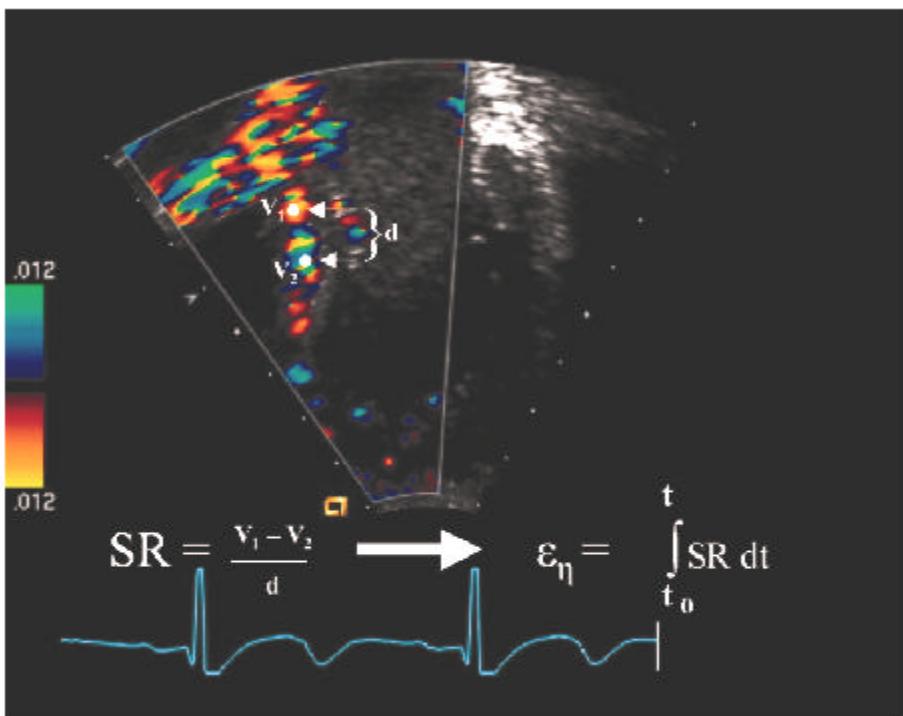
Apical 4 chamber image with color Doppler tissue velocity map superimposed on the 2-dimensional image along the ventricular septum. The calculations of regional strain rate (SR) and natural strain (ϵ_{η}) are described. Myocardial SR is the difference of 2 velocities ($V_1 - V_2$) divided by the distance (d) between the 2 points where the velocity information was extracted. Natural ϵ is measured by integrating SR over time.
